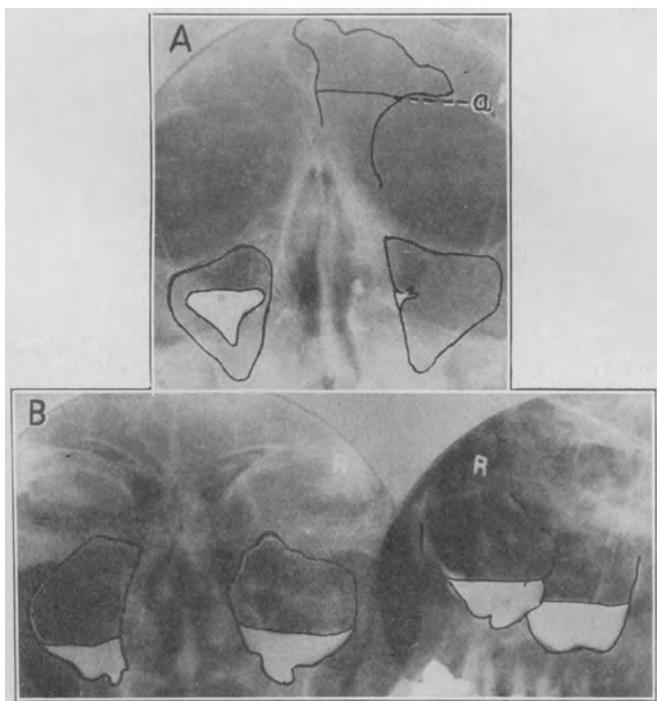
A man aged 74 had a history of an acute cold and bronchial cough of two weeks' duration. Very little oil was retained, as evidenced by roentgenogram *A*. Note the fluid level (*a*) in the right frontal sinus. Oil was injected again on the third, the sixth and the thirteenth day after the first injection. A check with oil and roentgenograms ten days later showed the sinuses to be clear and the filling of the antrum normal after four injections of iodized oil (*B*).
